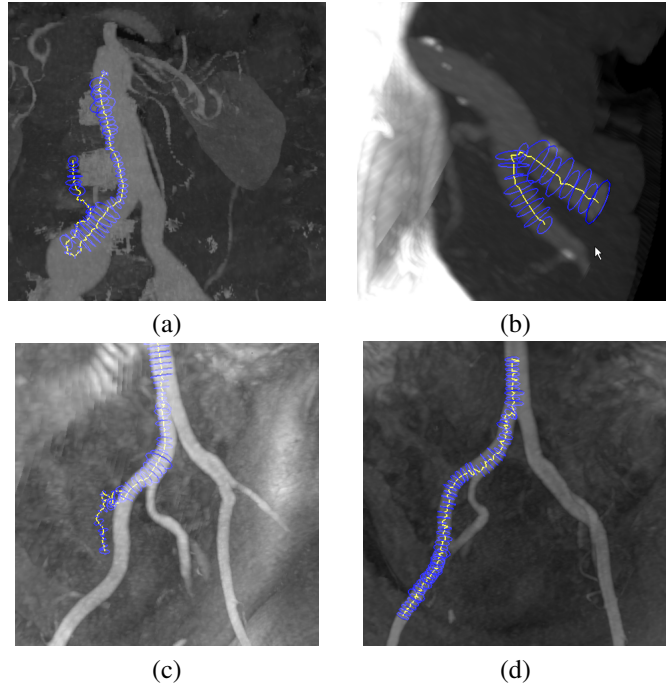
Common problem found during multi-scale extraction. (a) Wrong-scale selection / blob-like structure on aorta and iliac aneurysms on a CTA dataset. (b) Non-filtering of trajectory. (c) Excessive search radius on a MRA dataset. (d) Search radius limited in the same dataset.
